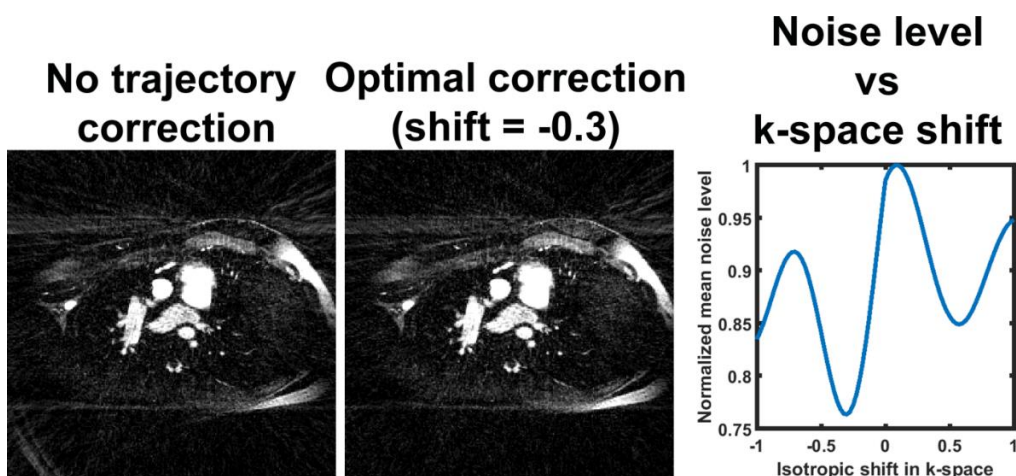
Representative QISS images without (default, left column) and with (middle column) gradient trajectory correction. (Right column) Mean normalized signal from background (i.e., signal-free region) plotted as a function of isotropic shift in k-space. This plot represents result from 6 pilot data from the same MRI system. This post-processing approach was used because the prototype QISS MRA acquisition did not separately acquire calibration data for gradient trajectory correction.
